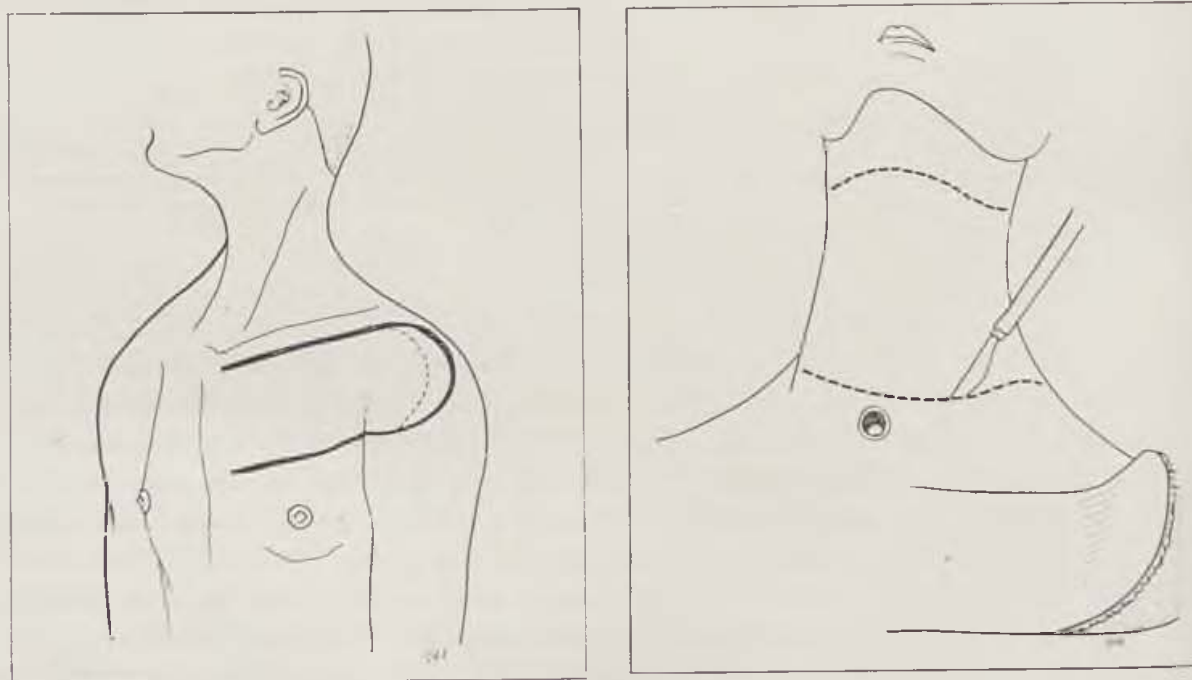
Deltopectoral flap based parasternally; upper incision follows the lower edge of clavicle, lower incision reaching 2—3 fingerbreadths above nipple. Flap apex is situated on shoulder joint front area. — Fig. 2 Broad cervical bridge flap and deltopectoral flap mobilization on the left. Tracheostoma was made to the right of the median line
